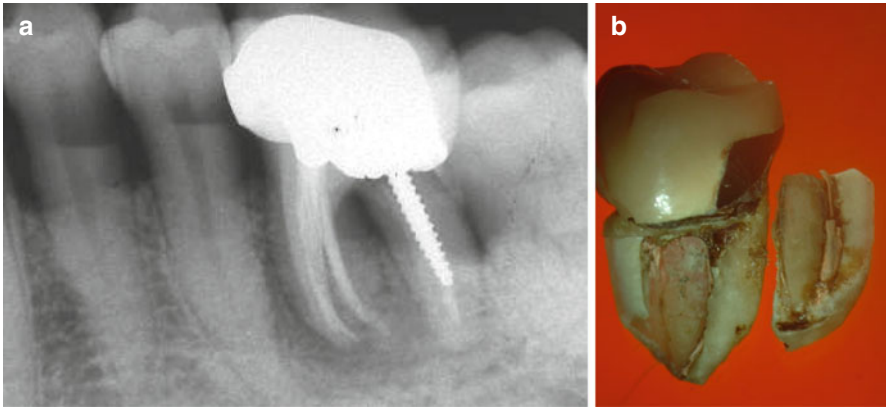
(a, b) The patient arrived at the dental office with a chief complaint of recurrent abscesses in the past year. The left mandibular molar was tender to percussion and palpation, and cl II mobility was also noted. An 8 mm probing defect was recorded in the mesiobuccal area and 5 mm in the midbuccal. The periapical radiograph (a) showed a previously treated mandibular molar, gutta-percha-filled root canals, a Dentatus dowel in the distal root, an amalgam dowel in the mesial, and full coverage with a crown. There was bone loss in the bifurcation and at the coronal half of the distal root. The mesial root was surrounded by a radiolucent lesion. A VRF was suspected and the tooth extracted. The typical buccolingual fracture can be seen in Fig. 5.1b
